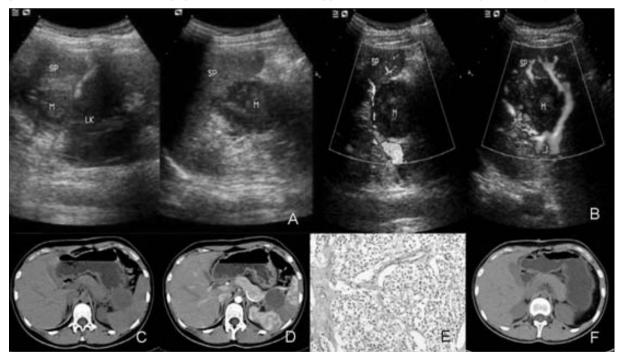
US revealed a well-circumscribed inhomogenous mass between the spleen and left kidney (A-B). CT demonstrated a predominantly cystic, well-encapsulated mass in the pancreatic tail causing splenic infarction (C). After contrast injection, the solid part of the tumor showed moderate to strong enhancement (D). The tumor showed proliferation in solid areas that alternates between a pseudopapillary and cystic pattern (E). The patient was followed up for 22 months without recurrence or metastases (F).
